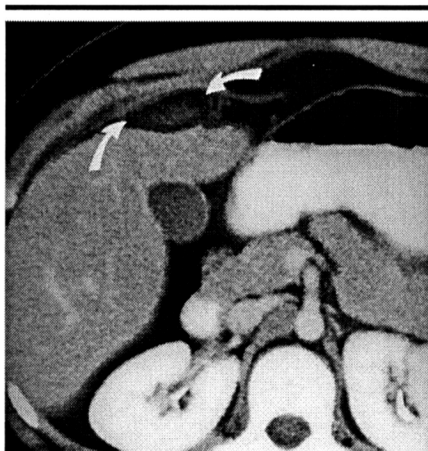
Segmental omental infarction. Transverse CT scan through the upper part of the abdomen after the administration of intravenous and oral contrast material in an 11-year-old girl with fever, leukocytosis, and acute right-lower-quadrant and midabdominal pain demonstrates an oval mass in the omental fat anterior to the liver, with associated inflammatory stranding (arrows) indicative of segmental omental infarction.
